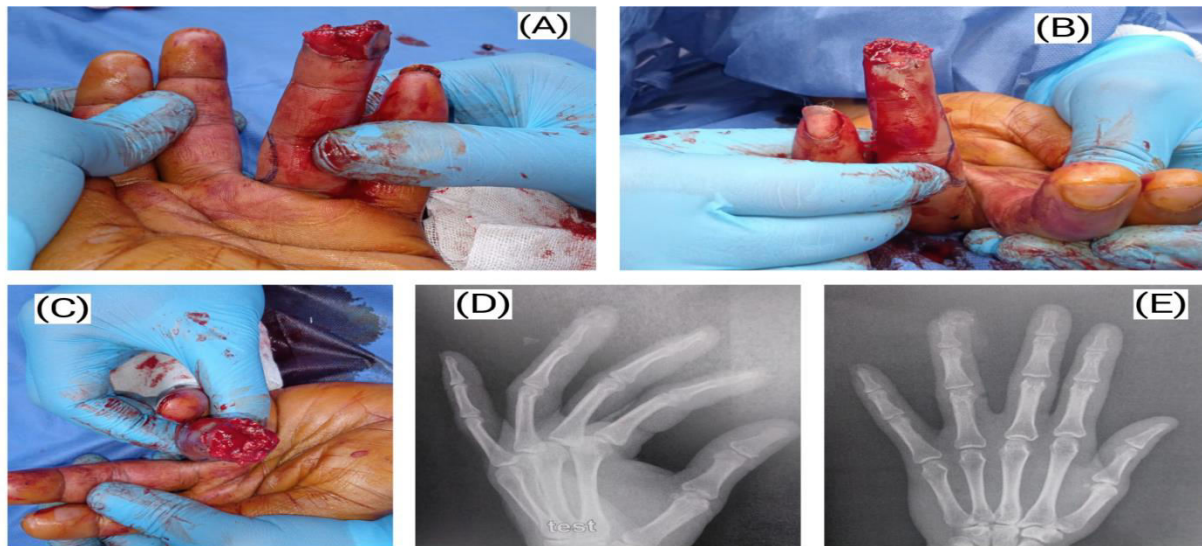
Oblique dorsal fingertip injury of left ring finger. (a) Volar aspect view. (b) Dorsal aspect view. (c) Finger tip injury with exposed bone. (d) Lateral view hand x-ray. (e) Antero-posterior view hand x-ray
